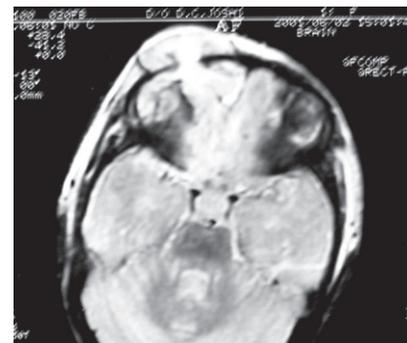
MRI (T1WI, axial) showing brain matter herniating under the scalp
